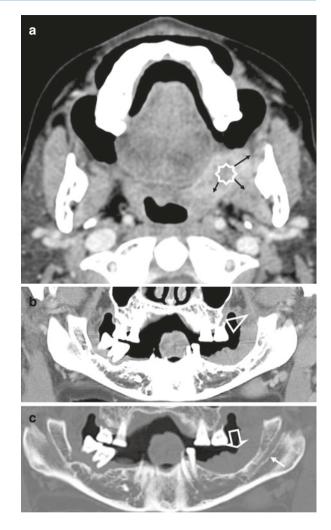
Sagittal image of CT (a) demonstrates enhancing lesion at floor of mouth (*black arrow*) adjacent to mandible. Axial bone window (b) shows inner cortical erosion (*open arrow*) Extent and depth of lesion is best demonstrated by curved reformation (c)
